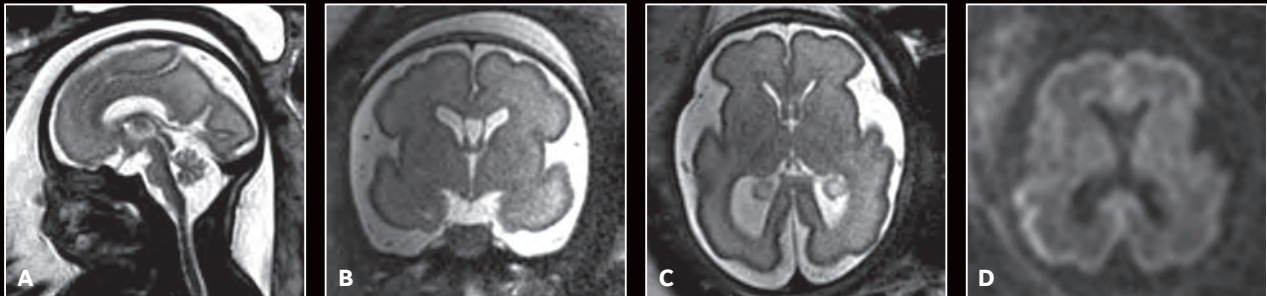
AIR Technology™ AA provides excellent signal penetration for high-quality images. (A) Sagittal T2 SSFSE; (B) Coronal T2 SSFSE; (C) Axial T2 SSFSE; and (D) Axial DWI b800.
